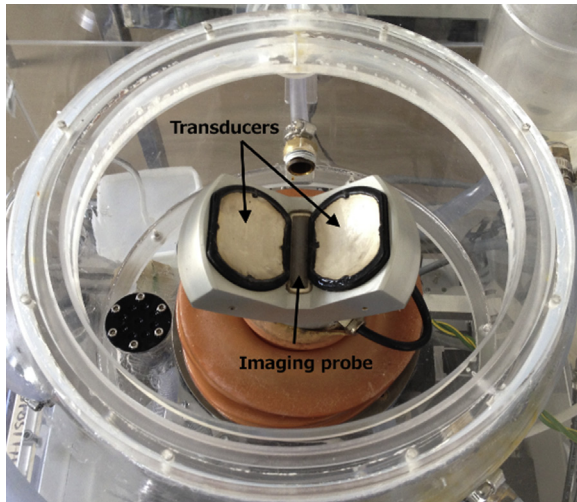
Confocal transducers and ultrasound imaging probe inside the water tank.
